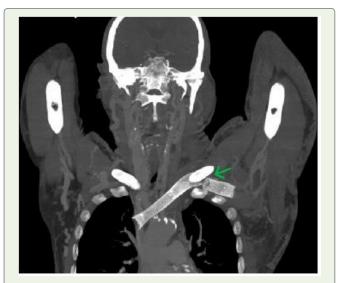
Computed tomography venography of thorax coronal reformatted maximum intensity projection mediastinal window image shows the fractured stents in the left subclavian vein, brachiccephalic vein, extending up to superior vena cava. The extensive collateral formation is noted because of the thrombosis of bilateral subclavian, brachiccephalic, and internal jugular veins.
